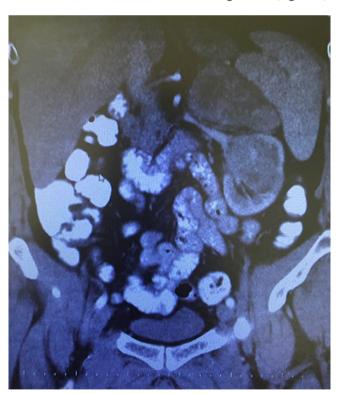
Computed tomography scan demonstrated a renal mass in left uppermid pole
